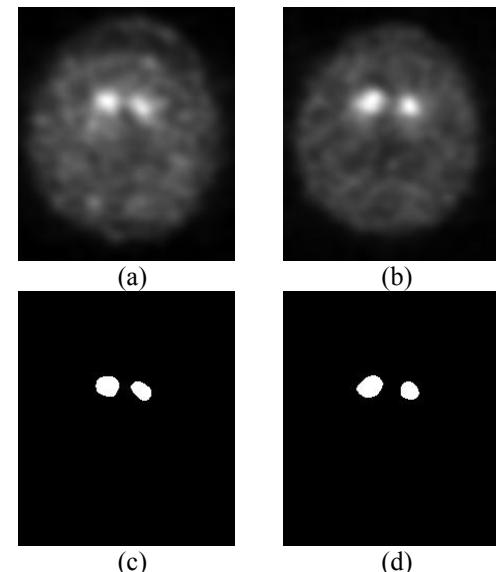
(a-b) representative sets of Parkinson's disease SPECT images and their corresponding segmented striatum region (c-d)
